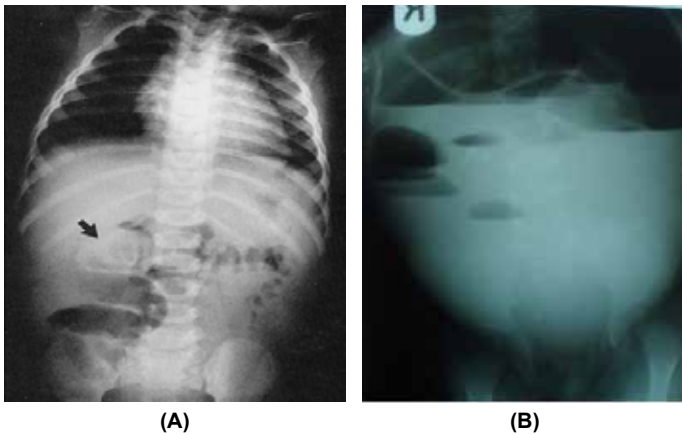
(A) Intussusception on plain abdominal x-ray showing the target sign. (B) Plain erect abdominal radiograph of a 6-month-old child with intussusception, showing multiple air-fluid levels consistent with intestinal obstruction.
